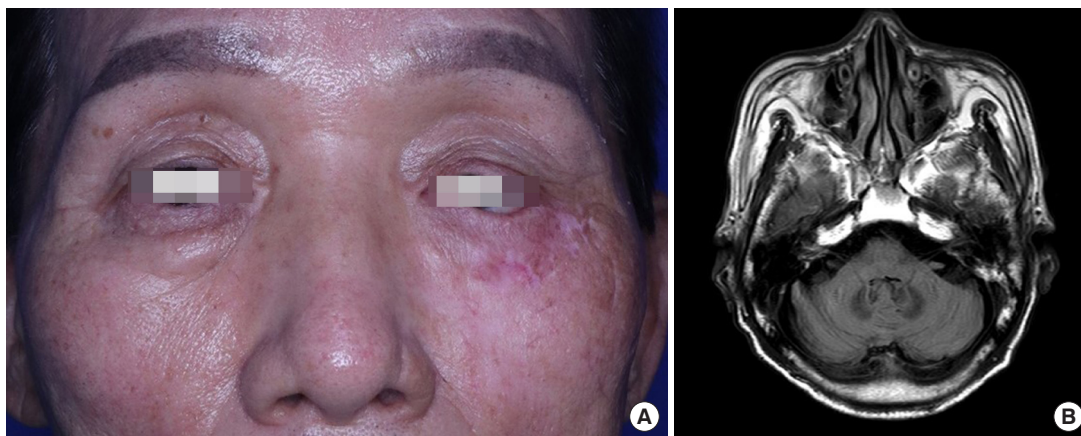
One-year postoperative images. (A) A photograph showing that there is no problem opening and closing his eyes. (B) T2-weighted magnetic resonance imaging with no evidence of recurrence.
